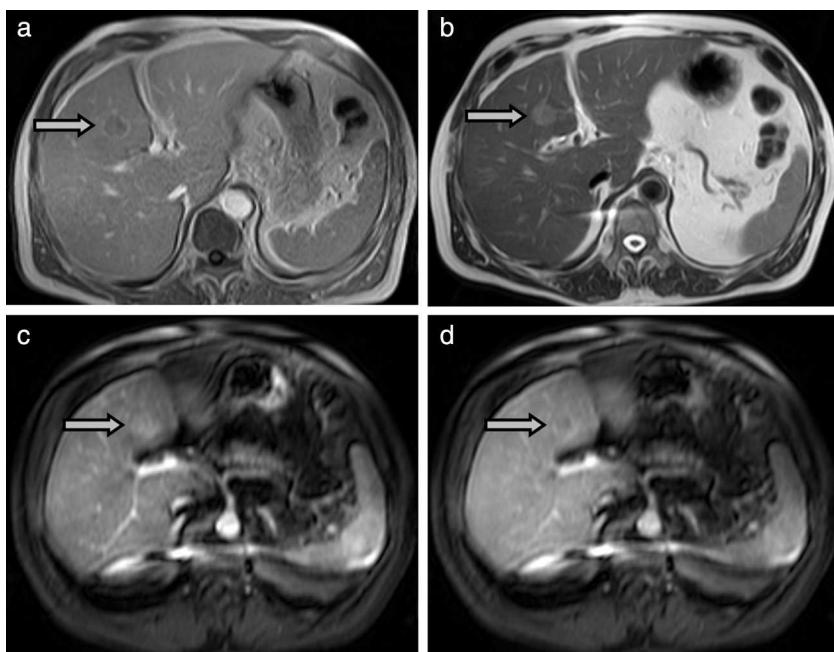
HCC during dynamic MRI (arrow): T1 weighted scan (a), T2 weighted scan (b), dynamic arterial phase (c), dynamic late phase (d).
